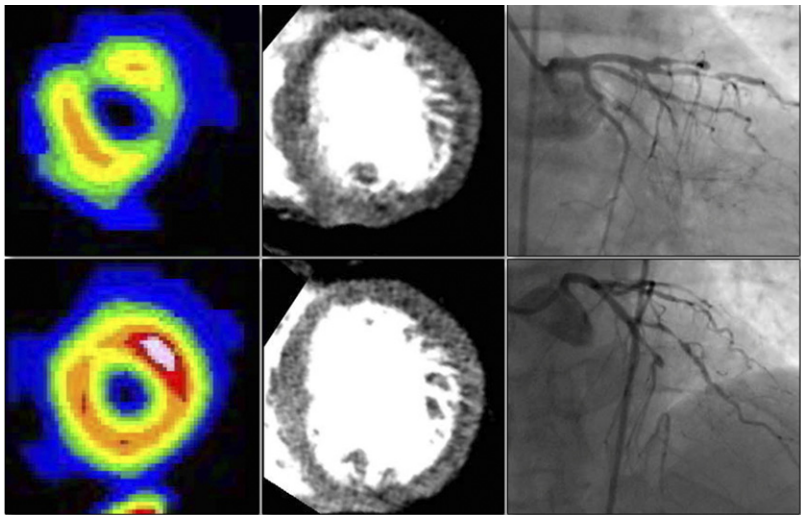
Comparison of CTP, SPECT, and Invasive Coronary Angiography
